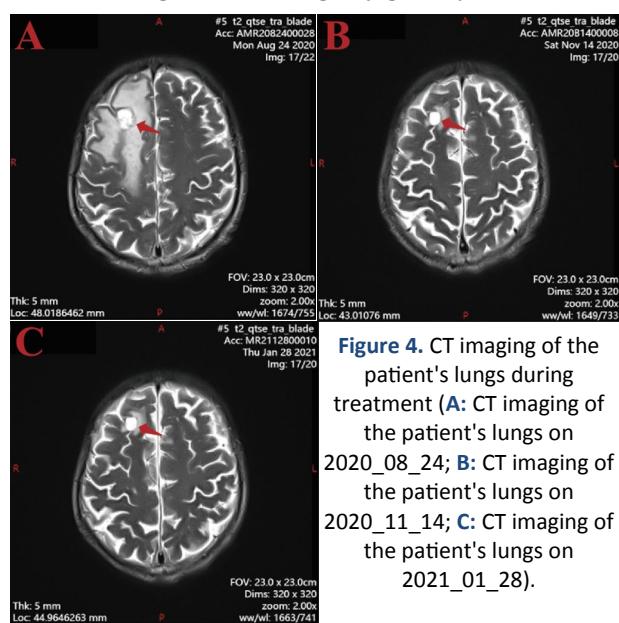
CT imaging of the patient's lungs during treatment (A: CT imaging of the patient's lungs on 2020_08_24; B: CT imaging of the patient's lungs on 2020_11_14; C: CT imaging of the patient's lungs on 2021_01_28).
